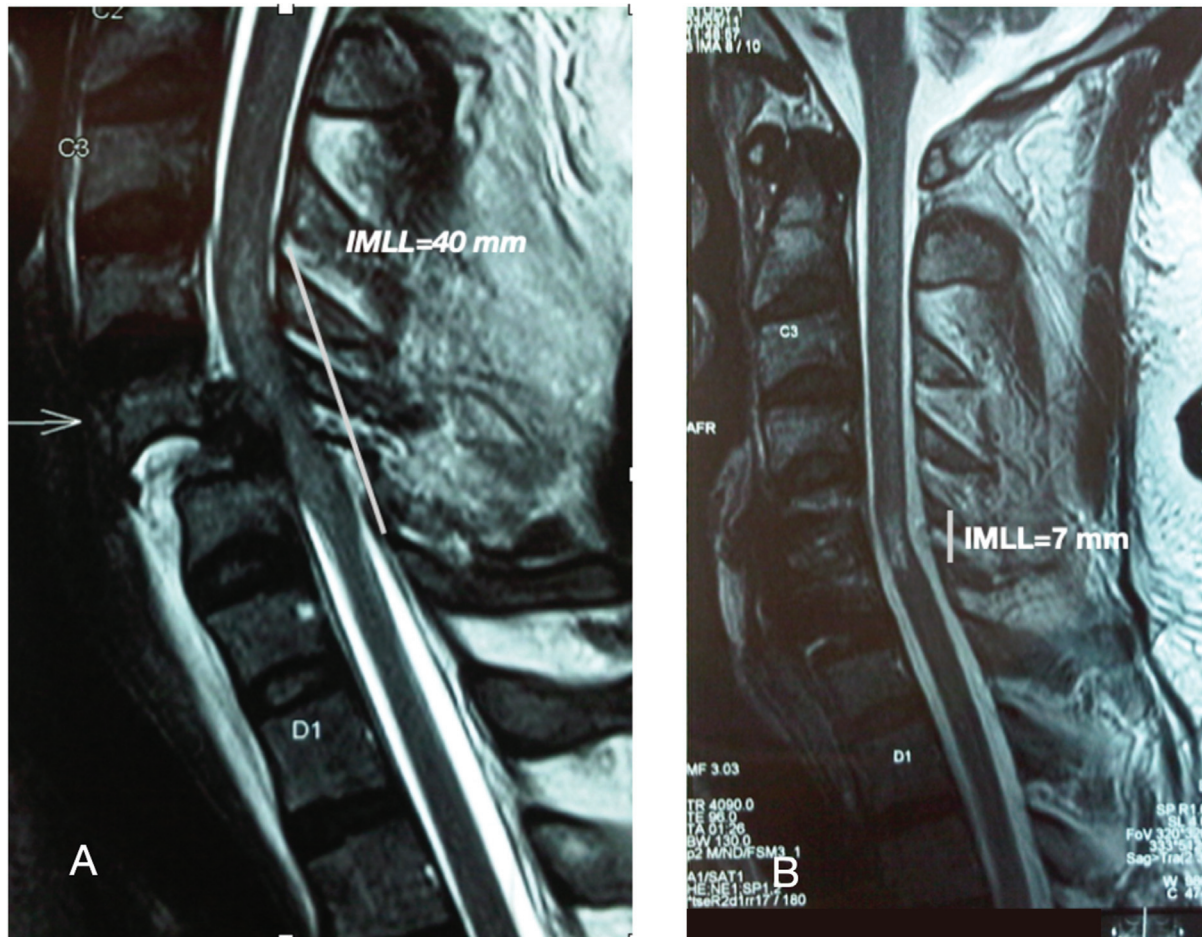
Pre- and postoperative, midsagittal magnetic resonance imaging (MRI) images of a 44-year-old man who was tetraplegic following cervical injury as a result of a fall from the first floor. His American Spinal Injury Association scale (ASIA) Impairment Scale (AIS) grade was A. Preoperative MRI showed a C5–C6 fracture dislocation, severe spinal cord compression, and an intramedullary lesion of a length of 40 mm (A). The patient underwent realignment of the spinal column with C5 corpectomy and anterior cervical plate fixation. His postoperative MRI shows a significant reduction in intramedullary lesion length of 7 mm (B). His AIS grade improved after 6 months to AIS grade C.
